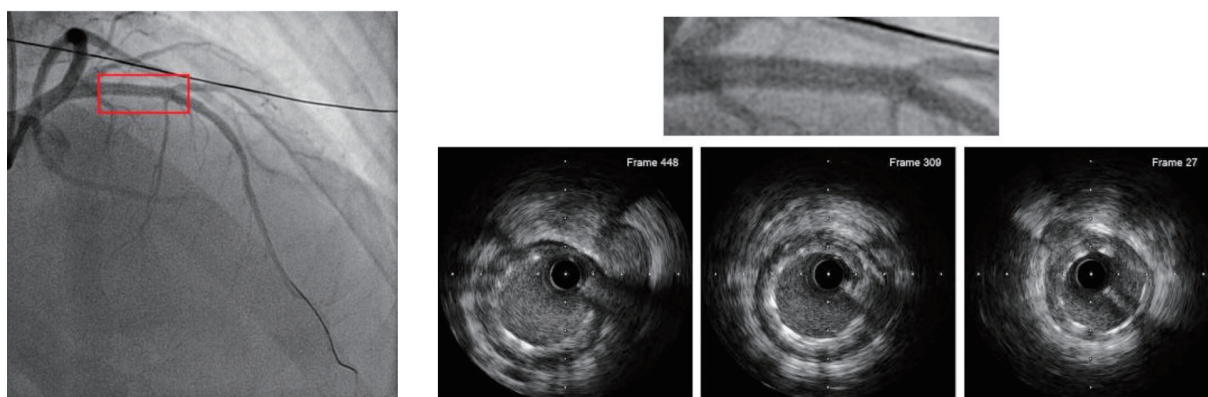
Final angiography (left). Intravascular ultrasound of the proximal, middle and distal region of the stented and post-dilated LAD region.
